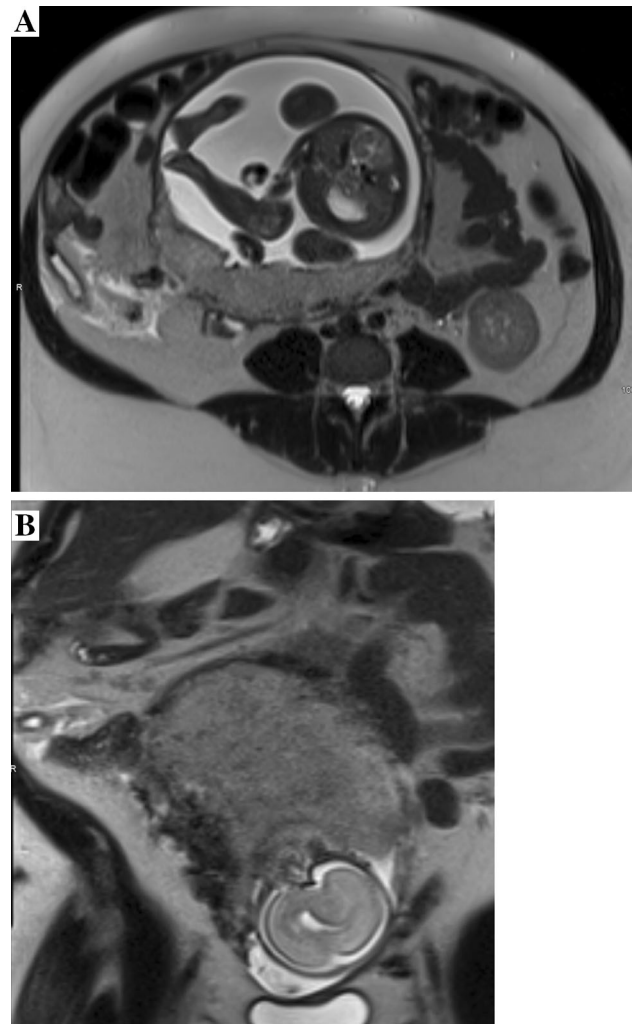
30-year-old pregnant woman with right mid and lower quadrant pain, fever, elevated serum white blood cell count, and acute appendicitis. Axial (a) and coronal (b) T2 HASTE MR images reveal the fluid-filled T2 hyperintense lumen of a diffusely thickened appendix in the right lower quadrant, with a lumen diameter of 11 mm, and periappendiceal fat stranding. A tiny appendicolith is seen as a focus of T2 low signal in the lumen of the appendix. Note the gravid uterus
